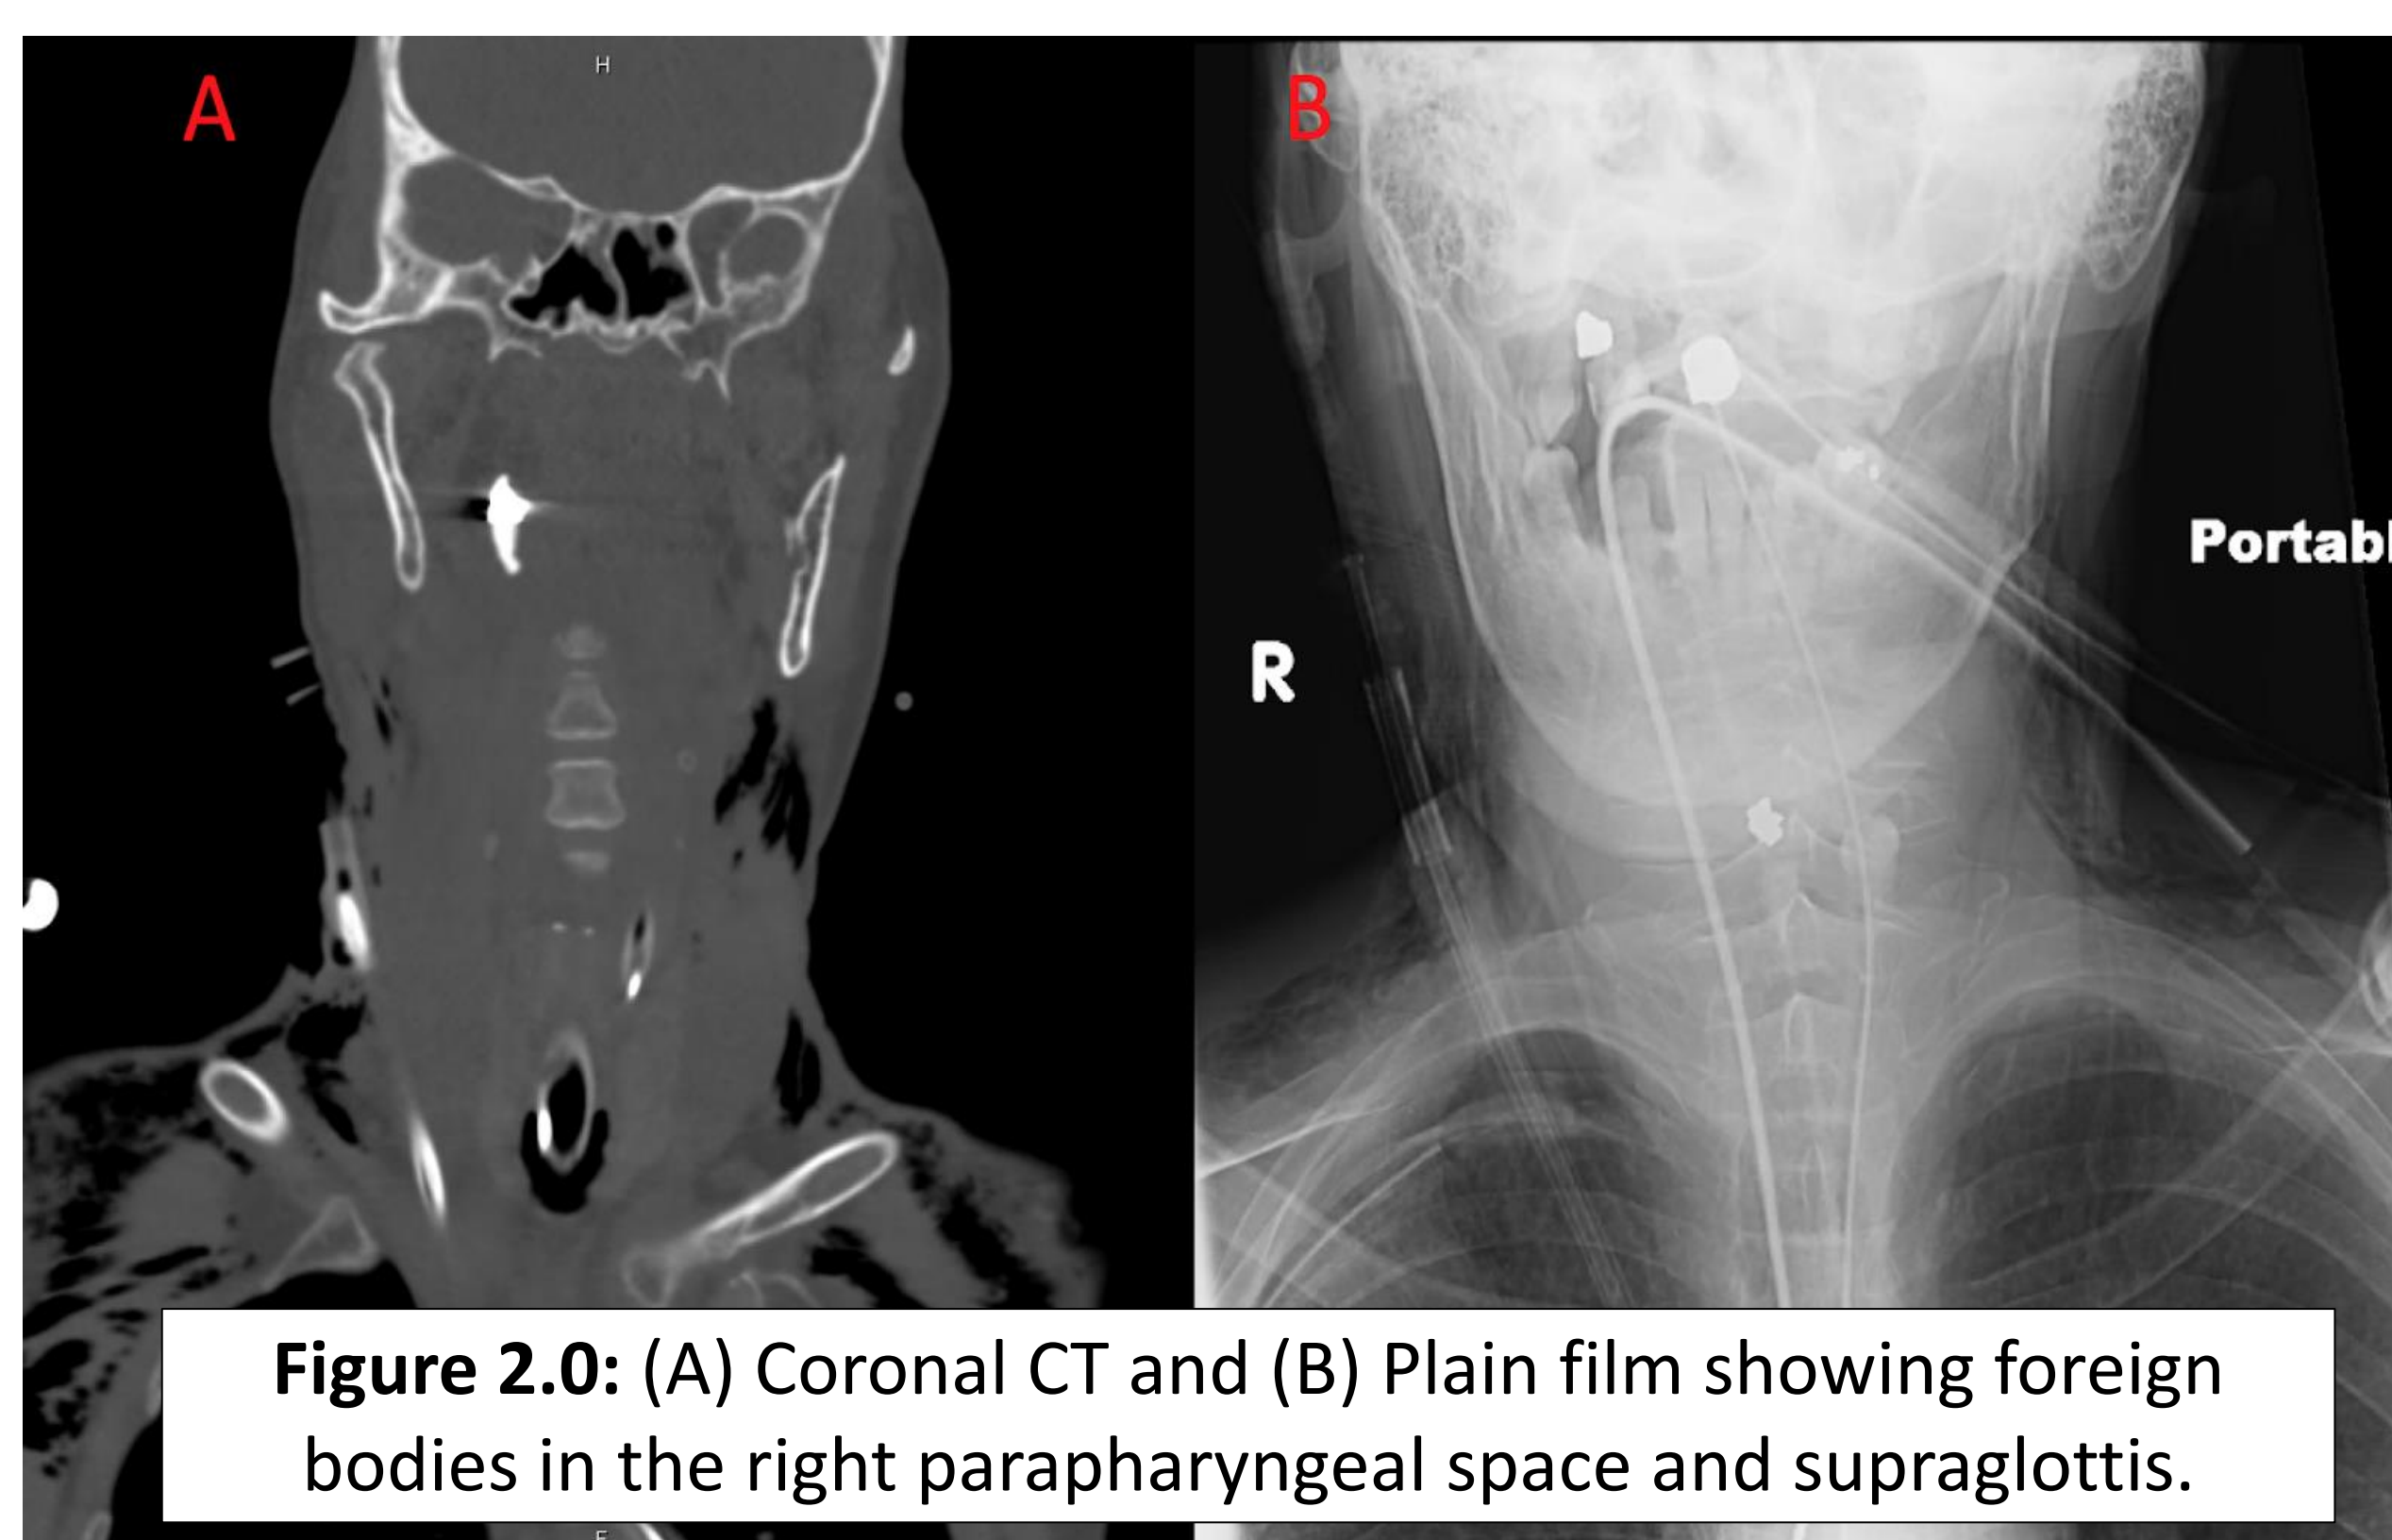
(A) Coronal CT and (B) Plain film showing foreign bodies in the right parapharyngeal space and supraglottis.
